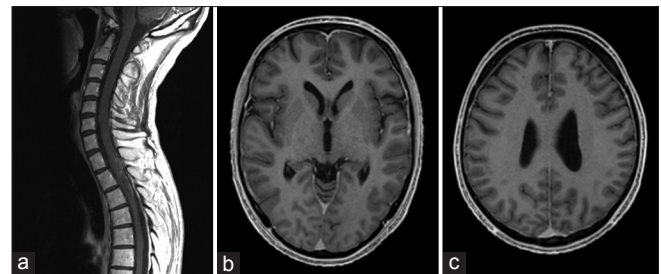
(a-c) Gadolinium-enhanced T1-weighted MR images showing marked reduction in the size of the enhanced lesion of the spinal cord (a) and the disappearance of the periventricular dissemination (b, c)
